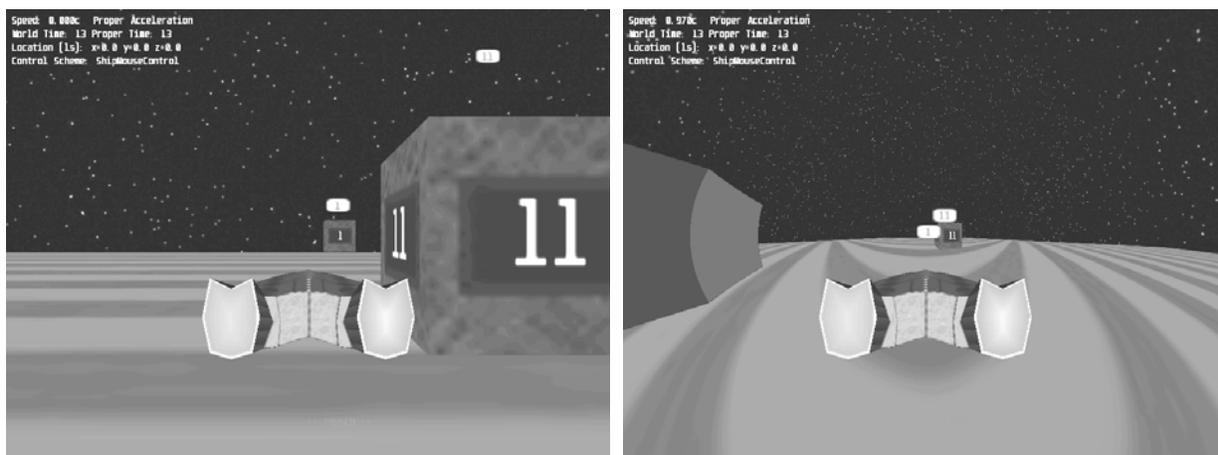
Screenshot from *RTR* showing 2 clocks from the same location and angle when stationary (left) and when travelling at near-light-speed (right). Headlight and Doppler effects are turned off here.
